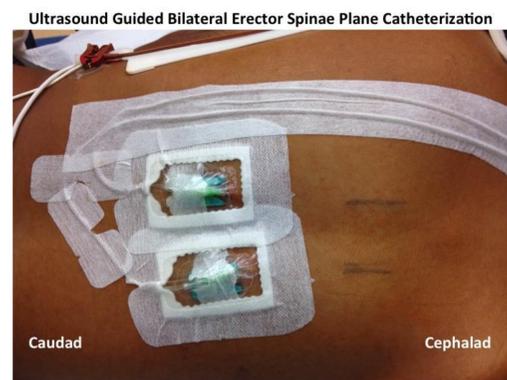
Stabilization of Ultrasound Guided Bilateral Erector Spinae Plane Block Catheters
